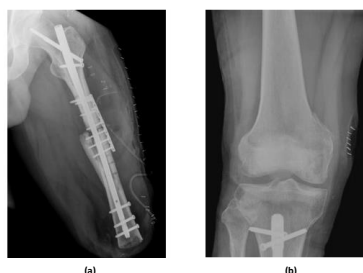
The plain film image of left femur after revision operation; (b) The plain film image of right femur after screw removal.
